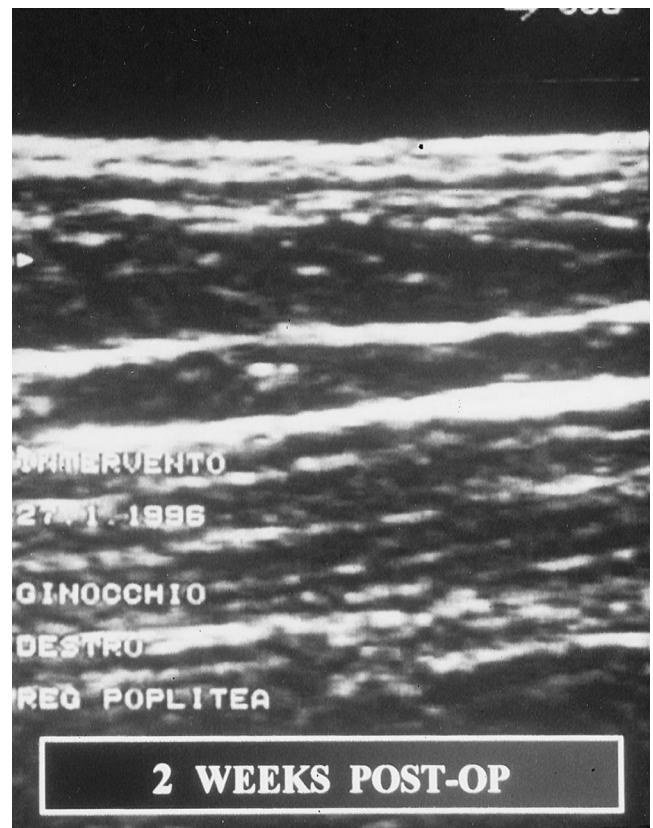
Two weeks after surgery the semitendinosus tendon was absent (longitudinal sonogram).
